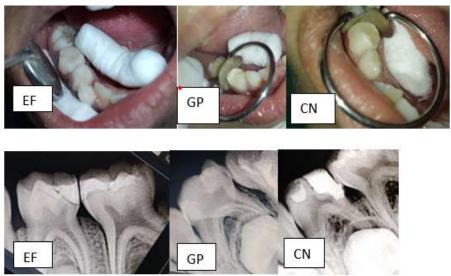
Clinical and radiographical representation of cavities restored with EQUIA Forte Fill [EF], G Aenial Posterior [GP], Cention N [CN].
